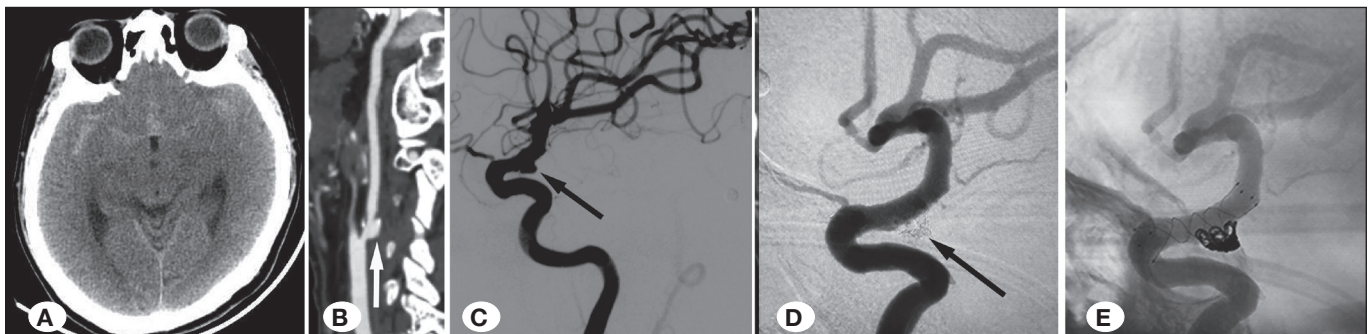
Images of the first procedure (August 2017). A) Brain CT revealed subarachnoid hemorrhage. B) CTA revealed approximately 80% eccentric stenosis with a dissecting aneurysm at the cervical segment of the right internal carotid artery. C) DSA revealed a ruptured, wide-neck, irregular aneurysm at the posterior communicating segment of the right ICA. D, E) Immediate post-procedural angiography confirmed complete occlusion with no residual neck.
